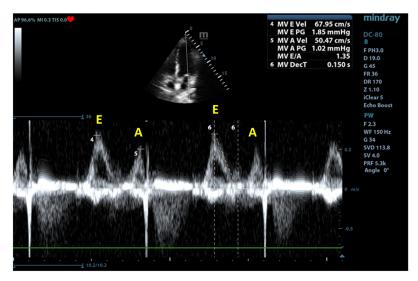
Figure nr. a.2.3. Evaluation of normal transmitral diastolic flow. E= maximum velocity of early diastolic filling (67.95 cm/s); A= maximum velocity of late diastolic filling (50.47 cm/s); E/A=1.35 (PW Doppler, apical 4-chambers view)
